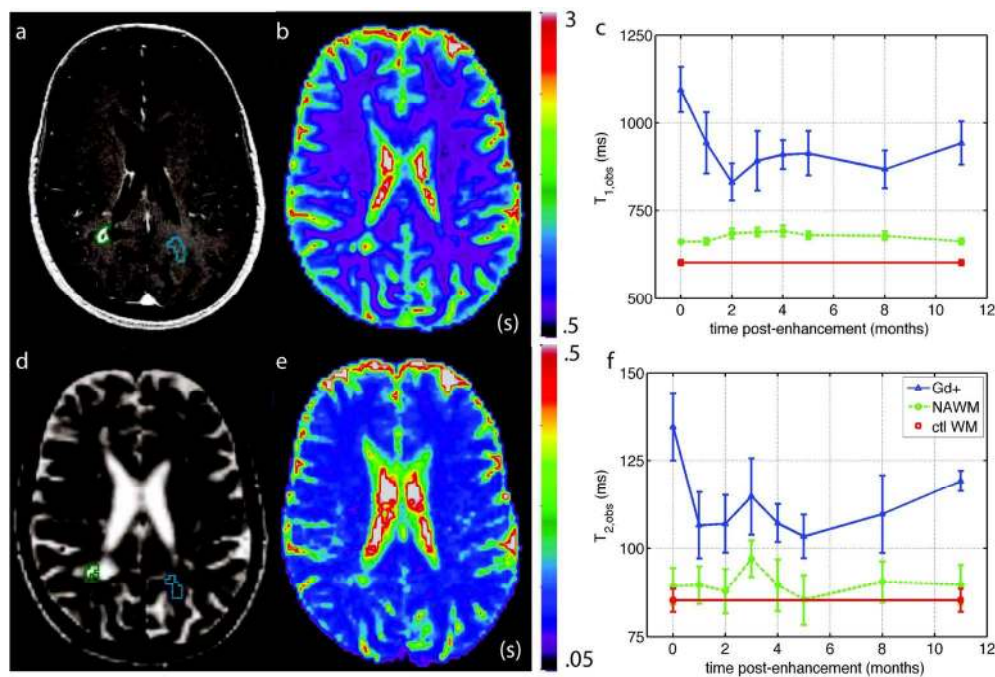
a) Initial post-Gd T1-weighted scan of a single patient with outlines of enhancing region (green) and contralateral NAWM (cyan) b) T1 map of the same subject (units are s) c) Plot of T1, averaged across five subjects at 8 time-points distributed over 12 months, starting at initial Gd enhancement. Error bars indicate the standard error of the mean across subjects d) T2-weighted image resampled to the lower resolution of the quantitative maps e) T2 map of the same subject (units are s) f) Plot of T2, averaged across five subjects at 8 time-points distributed over 12 months, starting at initial Gd enhancement. Error bars indicate the standard error of the mean across subjects (adapted from Levesque et al. Magn Reson Med, 2010, 63:633-640; with permission). Gd = Gadolinium.
